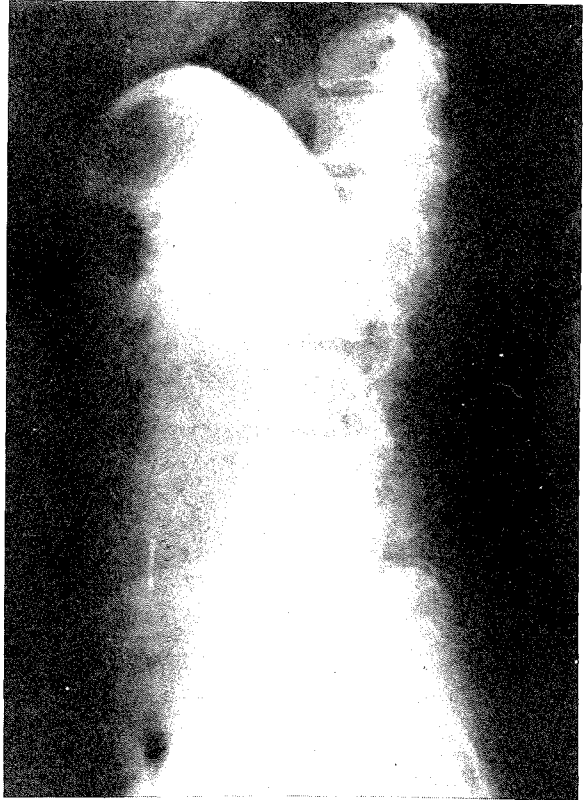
Lateral x-ray abdomen - The device is at the level of the fifth lumbar vertebra on standing.
